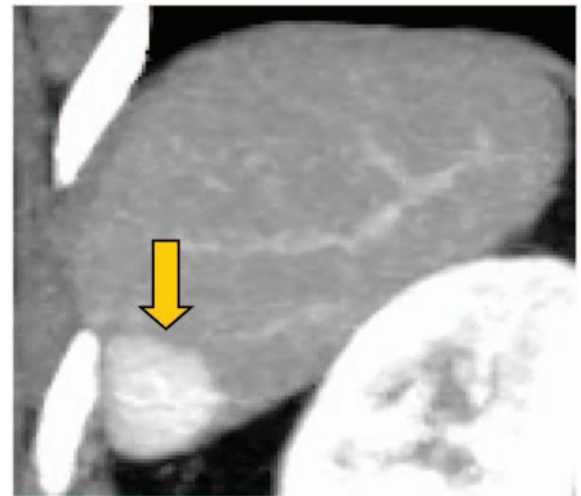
CT scan of the liver in the arterial phase. Note the enhancing lesion (arrow) consistent with hepatocellular carcinoma. Courtesy of Dr Dushyant Sahani.
